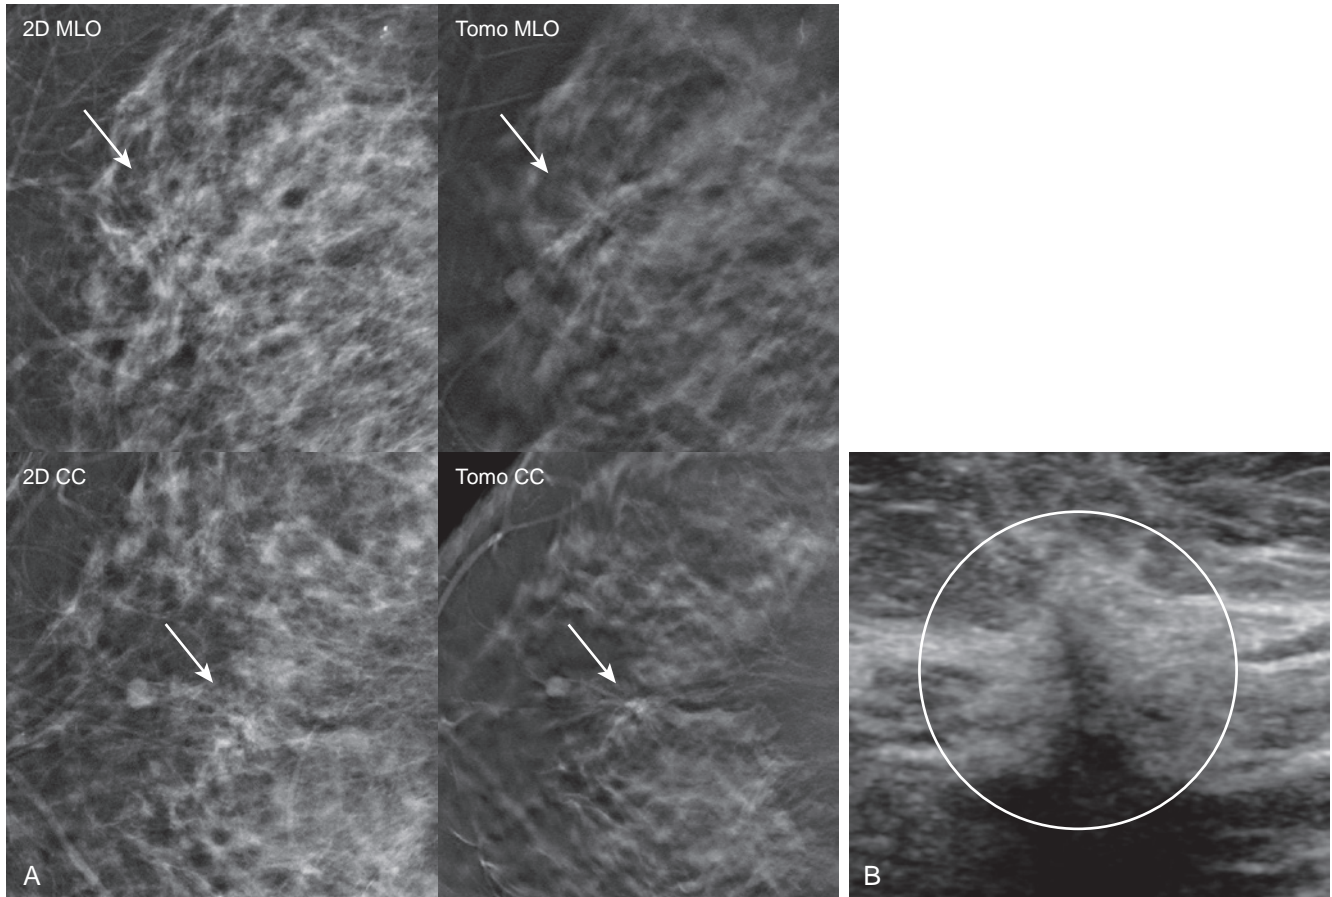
DCIS presenting as architectural distortion. (A) Diagnostic mammogram in a 67-year-old woman with a palpable mass in the left breast. Tomosynthesis reveals a subtle architectural distortion in the right breast at the 12-o'clock position, not seen on two-dimensional images (*arrows*). There were no other mammographic findings. (B) Targeted ultrasound reveals a corresponding subtle hypoechoic mass with indistinct margins and an antiparallel orientation (*circle*), BI-RADS 4C. Ultrasound-guided core needle biopsy and surgical excision yielded DCIS, grade 2 to 3 with necrosis, ER+/PR-.
